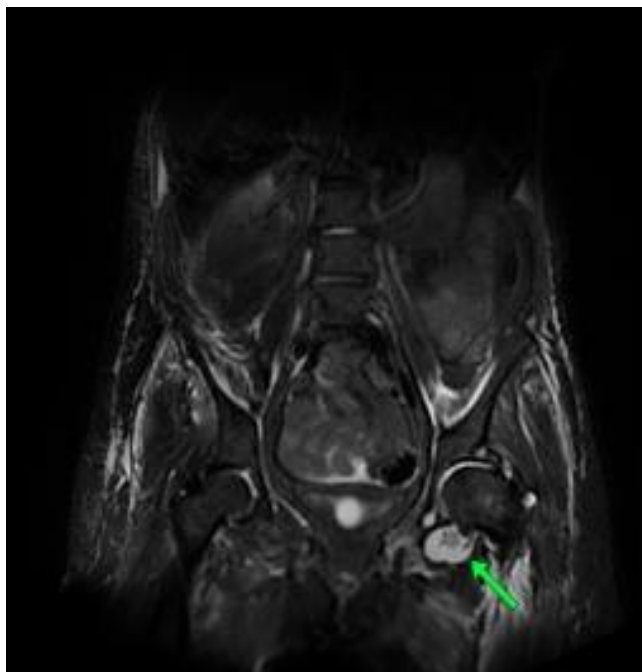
Intraarticular abscess, MRI coronal plane..
